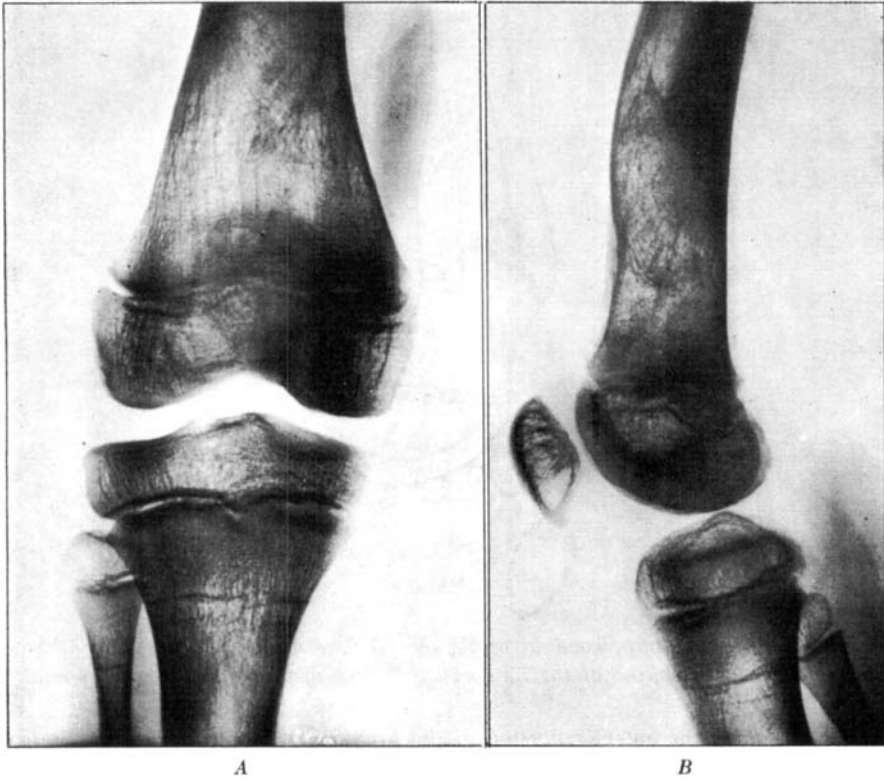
Case 1. A and B. Radiographs of the right knee. Age ten years.
